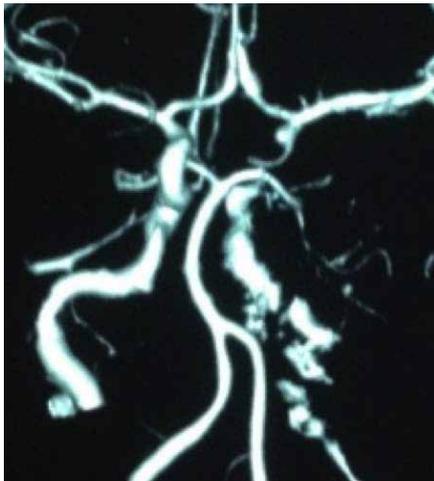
CT angiogram with 3D volumetric reconstruction image demonstrates non-opacification of cervical, petrous and cavernous segment of left ICA
